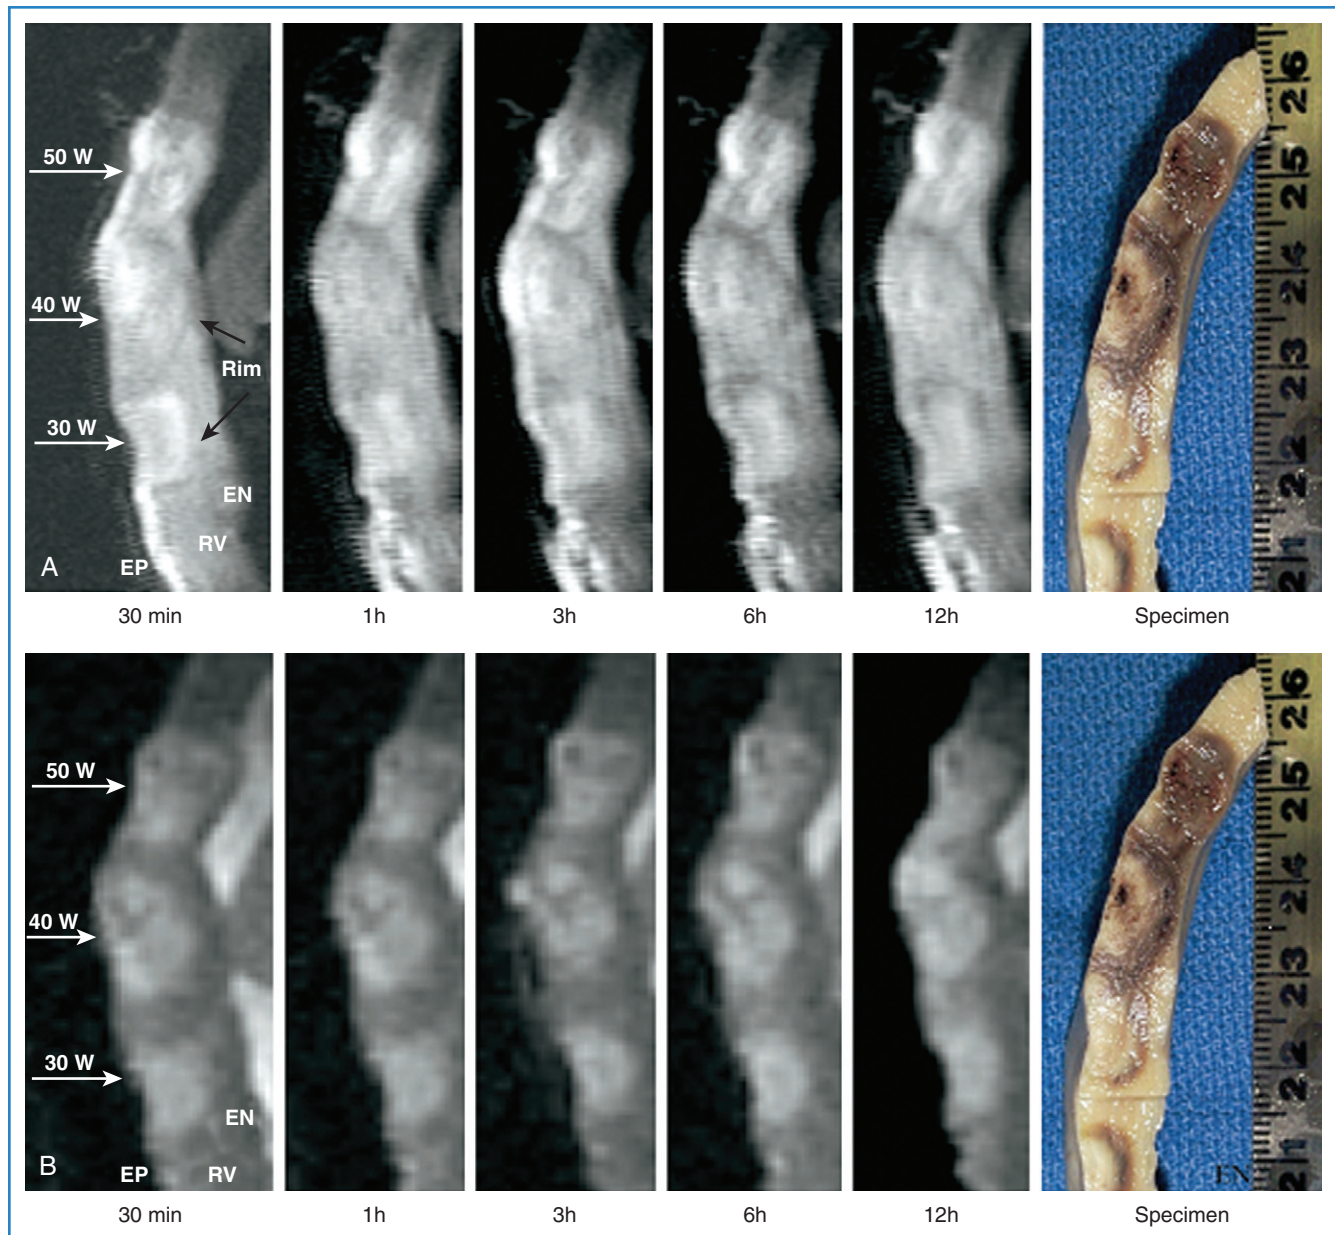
Appearance and time course of ablation lesions in non-contrast-enhanced magnetic resonance imaging. A, Typical appearance of ablation lesions using T2-weighted imaging protocols. Lesions can be seen as areas of increased signal intensity surrounded by hypodense rim. No significant change was found after a 12-hour follow-up. B, Corresponding images in T1-weighted images.
